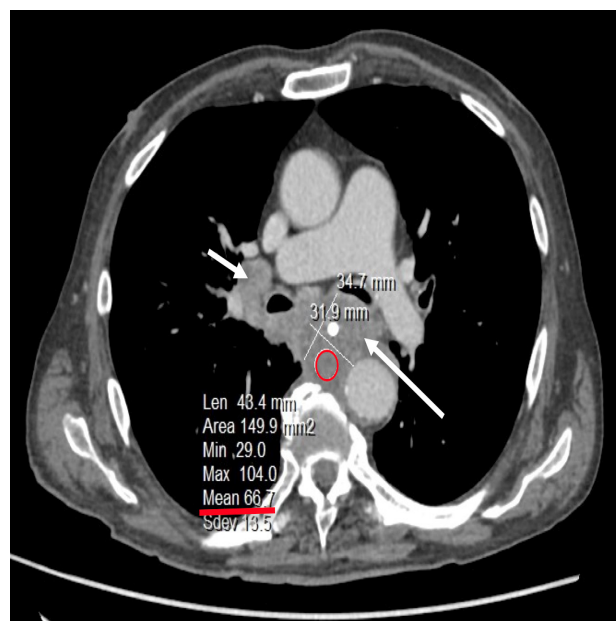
51-year patient's CT axial slice with CE demonstrate pathologic oesophageal masses and pathologic lymph nodes conglomerate below bifurcation (arrows). ROI (red ring) shows mean of attenuation 66,7 Hu after CE.
